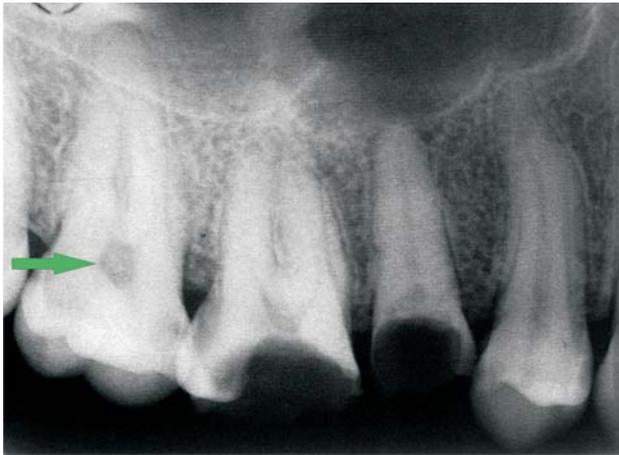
Retro-alveolar radiography of a 29-years-old patient. It is noticed the presence of a small-sized denticle situated on the level of the pulp chamber of the 2.7 molar, without noticing the presence of associated cavity or periodontal lesions
